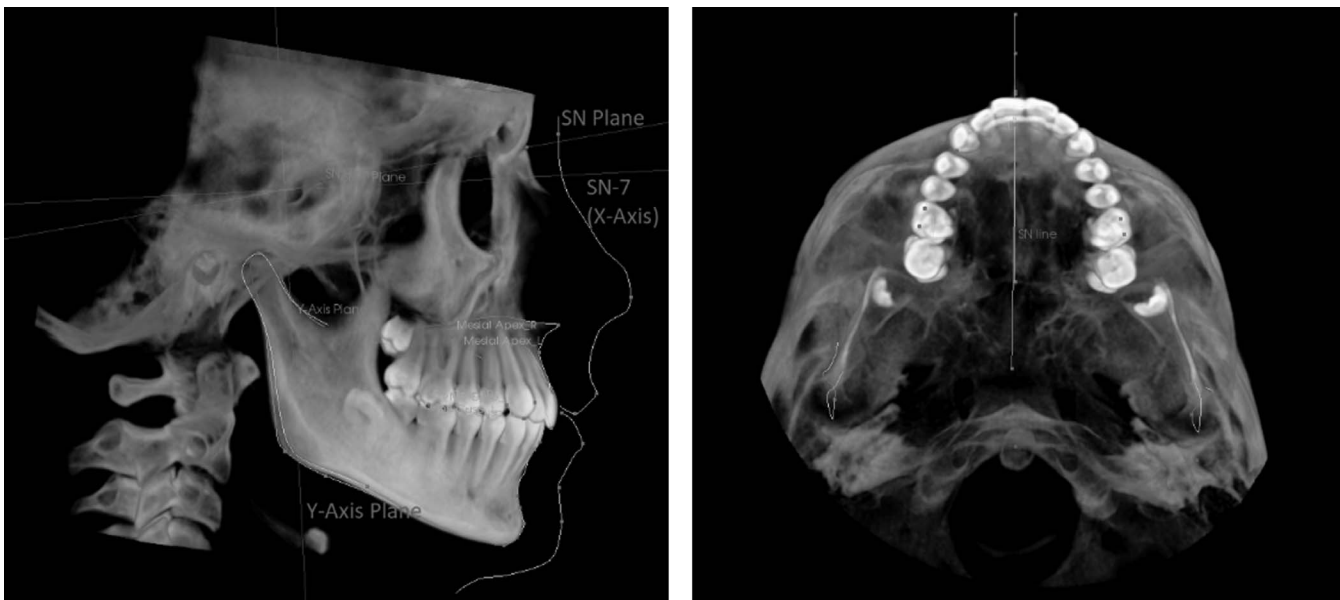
CBCT analysis in anteroposterior and transverse dimensions.
